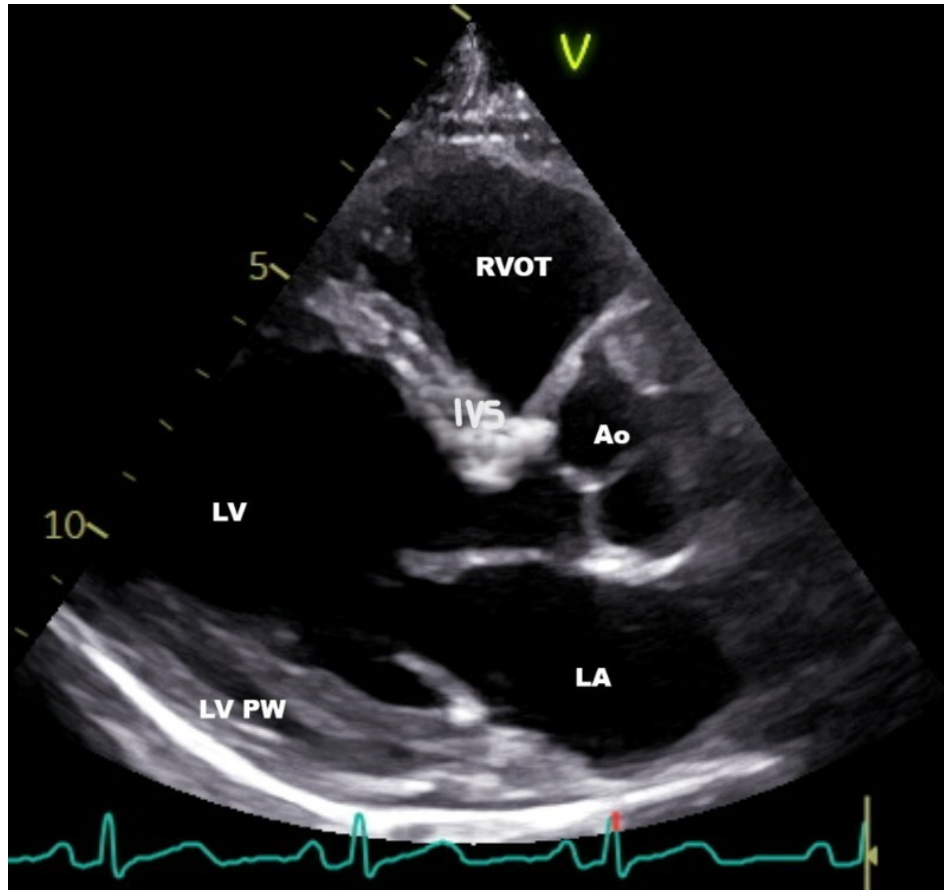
Parasternal long axis view. RV, Right ventricle; RVOT, Right ventricular outflow tract; LV, Left ventricle; LV PW, Left ventricular posterior wall; LA, Left atrium; AO, Aorta; IVS, Interventricular septum
